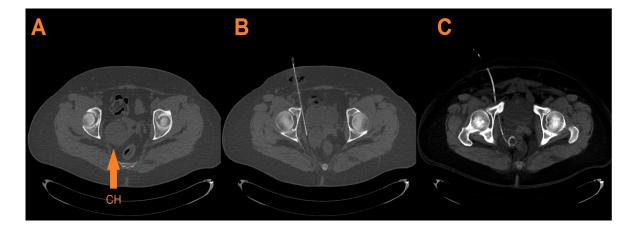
PD in Retrovesical hydatid cyst. A: Retrovesical hydatid cyst CT image; B: Retrovesical hydatid cyst accessing needle CT image; C: After the PD operation, the placement of the catheter into the cyst
